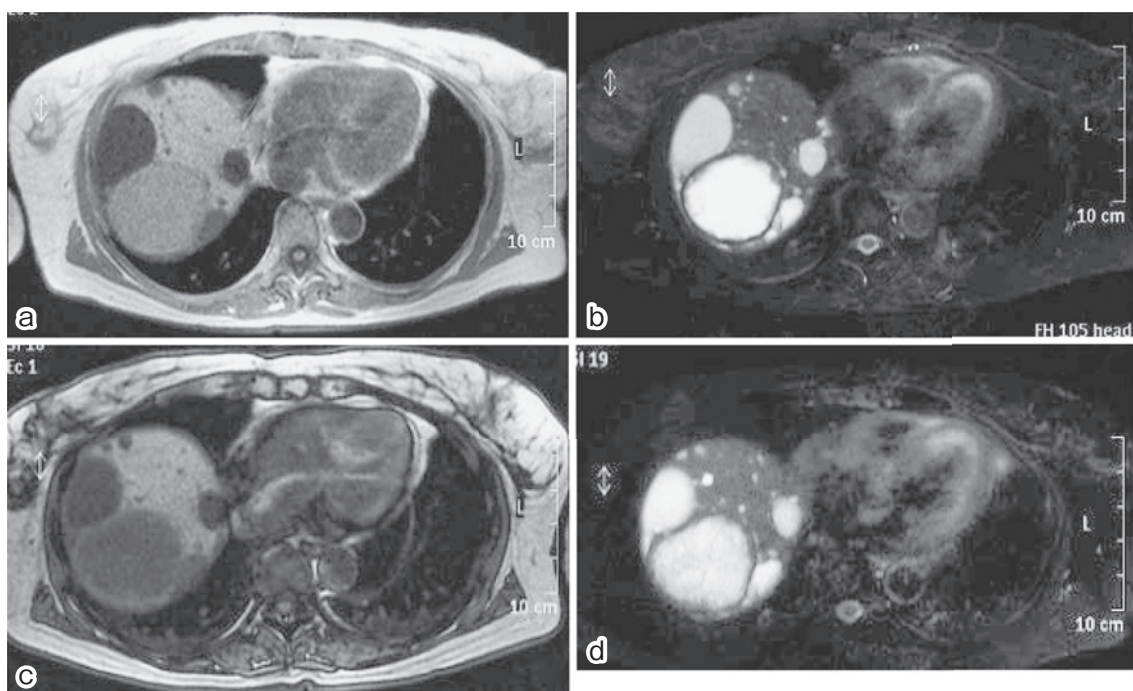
On magnetic resonance imaging (MRI), this cyst showed heterogeneous hyperintensity on T1- (a) and T2- (b) weighted sequences greater than that of the other hepatic cysts. On magnetic resonance imaging (MRI) 14 months later, the cyst showed heterogeneous hyperintensity on T1- (c) and T2- (d) weighted sequences which was less than that on the previous MRI scan.
